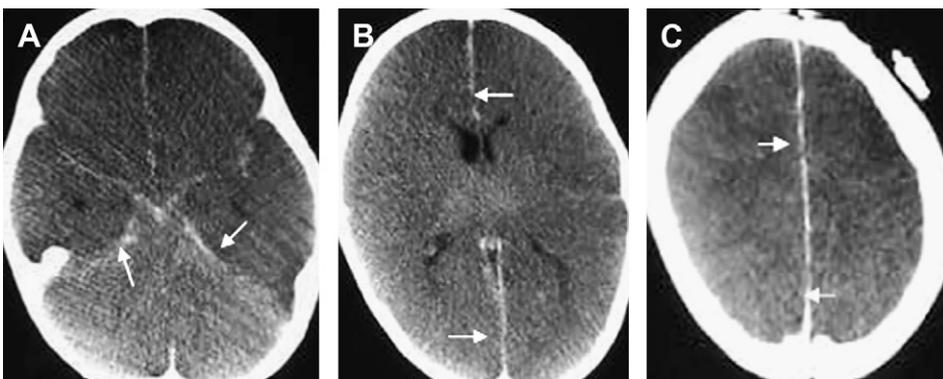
Twenty-one-month-old infant with triad and alleged NAI. Pneumococcal meningitis, herniation, and hypoxic-ischemic injury confirmed at autopsy. CT (A–C) shows high-density thin SDH (arrows) plus cerebral edema.
